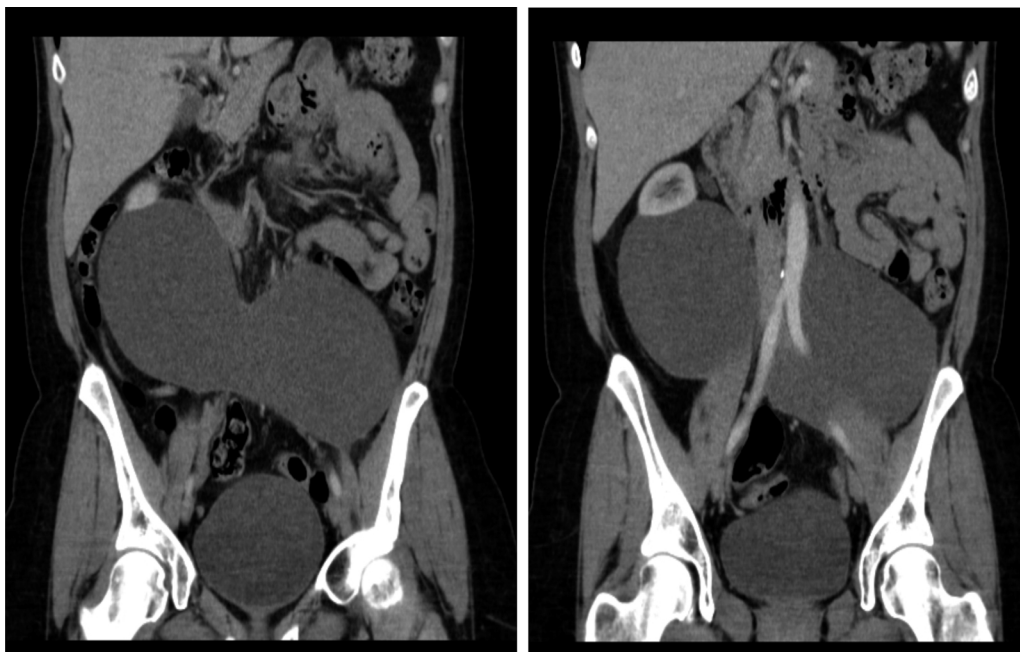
Coronal CT reconstruction on 2 slices: large bilateral lymphocele.
